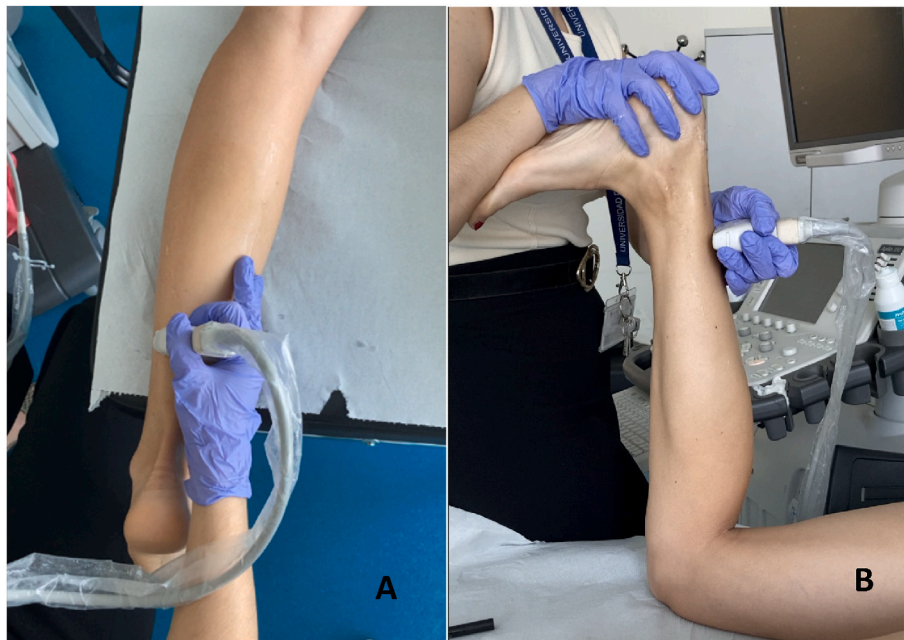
A) Ultrasound measurements at rest. B) Ultrasound measurements with passive force.
